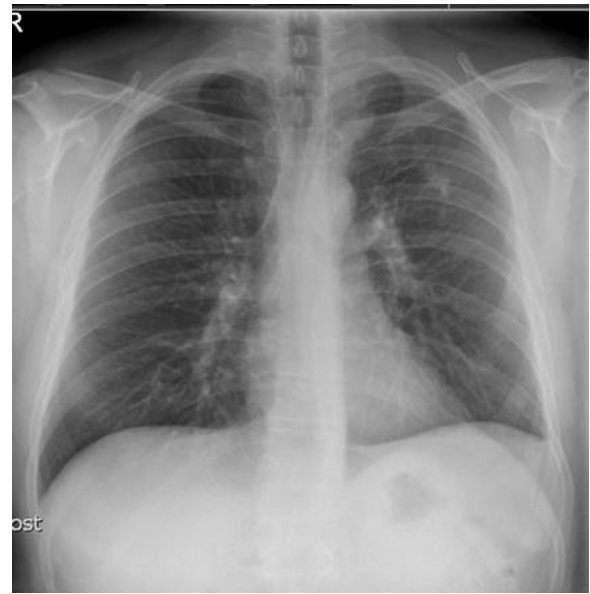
Post-operative chest radiograph prior to discharge.
